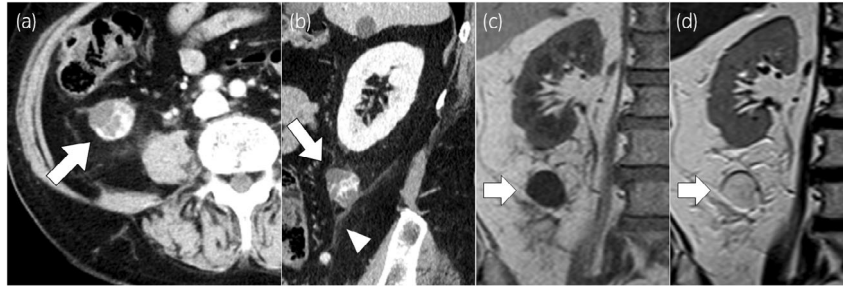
Contrast-enhanced abdominal CT images of the tumor in the (a) axial and (b) sagittal planes, and (c, d) MRI in the coronal plane. (a, b) The lobulated mass (27 mm in diameter, arrow) is in the right perirenal adipose tissue apart from the right kidney and major vessels. It shows heterogeneous and septal enhancement. The increase of the right perirenal adipose tissue density and thickening of the retroperitoneum (triangle) are shown. (c) The mass (arrow) shows a low signal compared with the cortex of the kidneys on a T1-weighted image and (d) an inhomogeneous high signal on a T2-weighted image.
